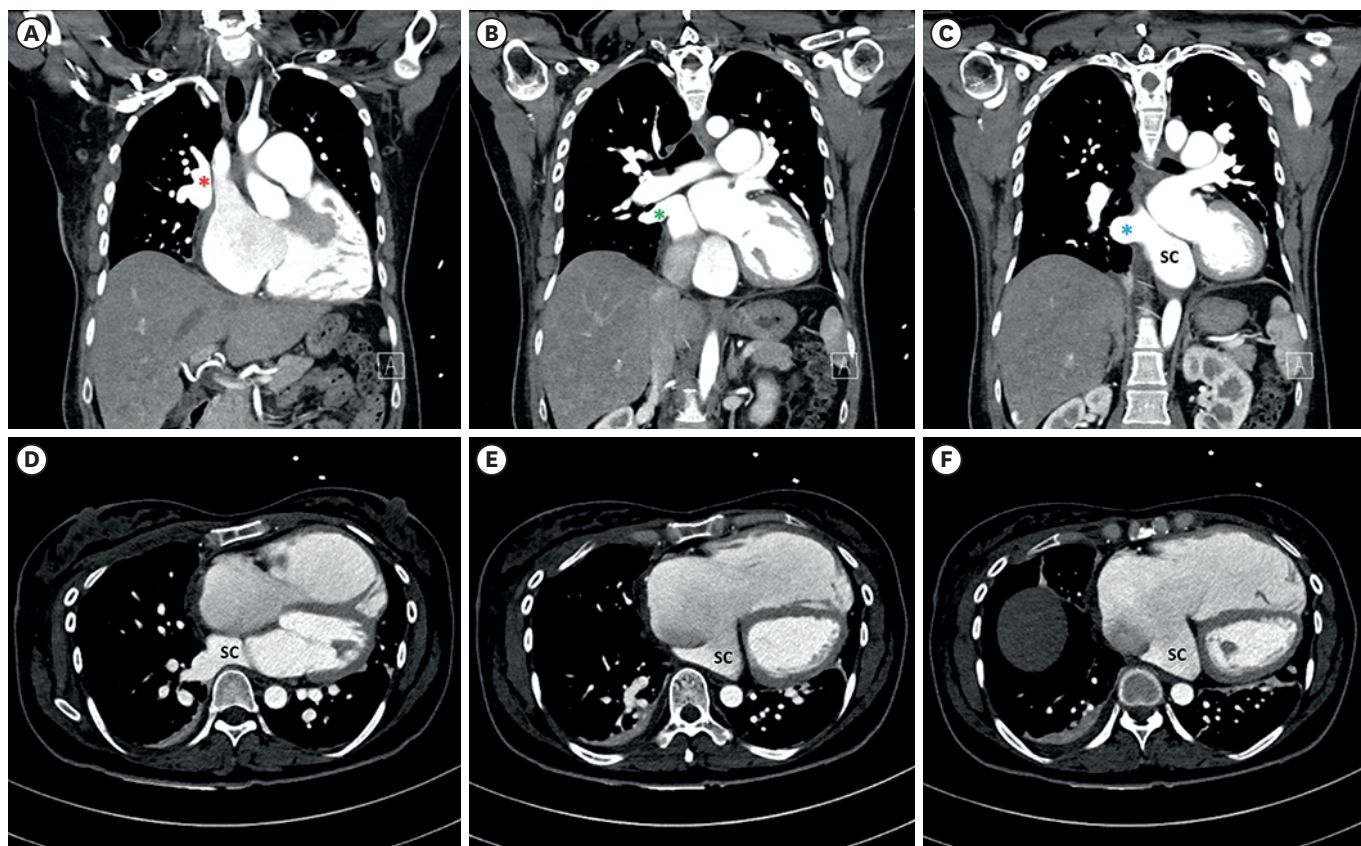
(A-C) Computed tomography with coronal planes (from the shallow to the deep plane), the right upper (red asterisk), middle (green asterisk), and lower pulmonary veins (blue asterisk) coalesce into the SC. (D-F) Cut-by-cut transverse planes reveal that the scimitar vein courses behind the interatrial groove and drains into the right atrium. SC: scimitar vein.
